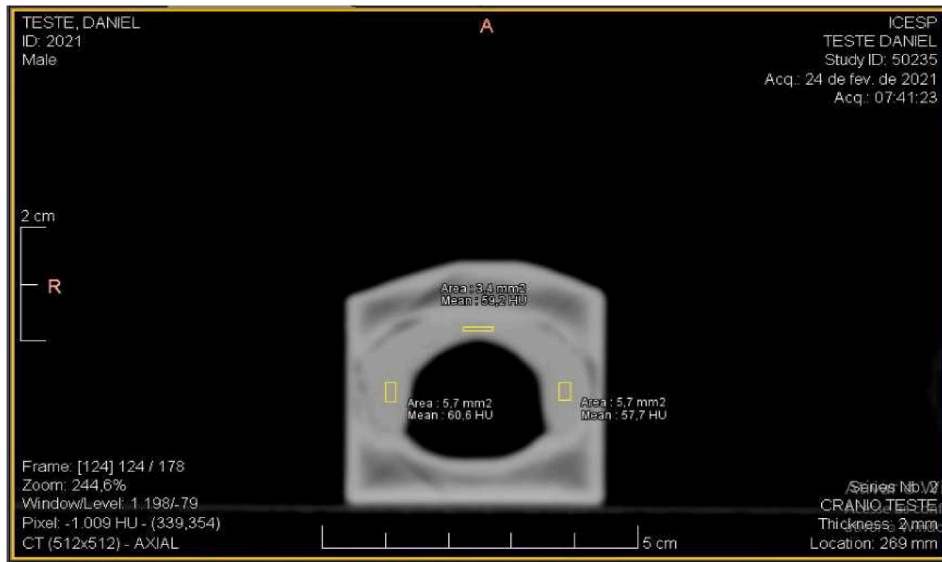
Investigation of the CT numbers obtained for the epoxy resin incorporated into the 3D printed thyroid accessory.
